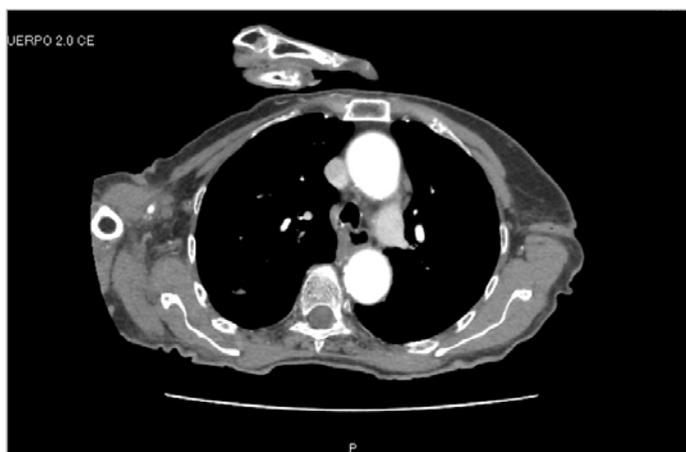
Third CT (after treatment).
